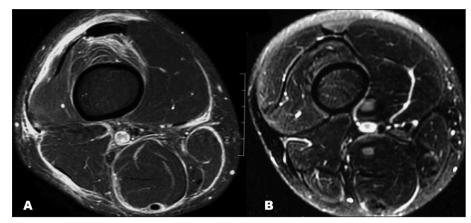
(A) MRI of the right knee showing edema of soft adjacent parts to the muscular bellies of the evaluated segment, of circunferencial aspect, and there was intense contrast enhacement. (B) Control MRI of his right knee was normal
